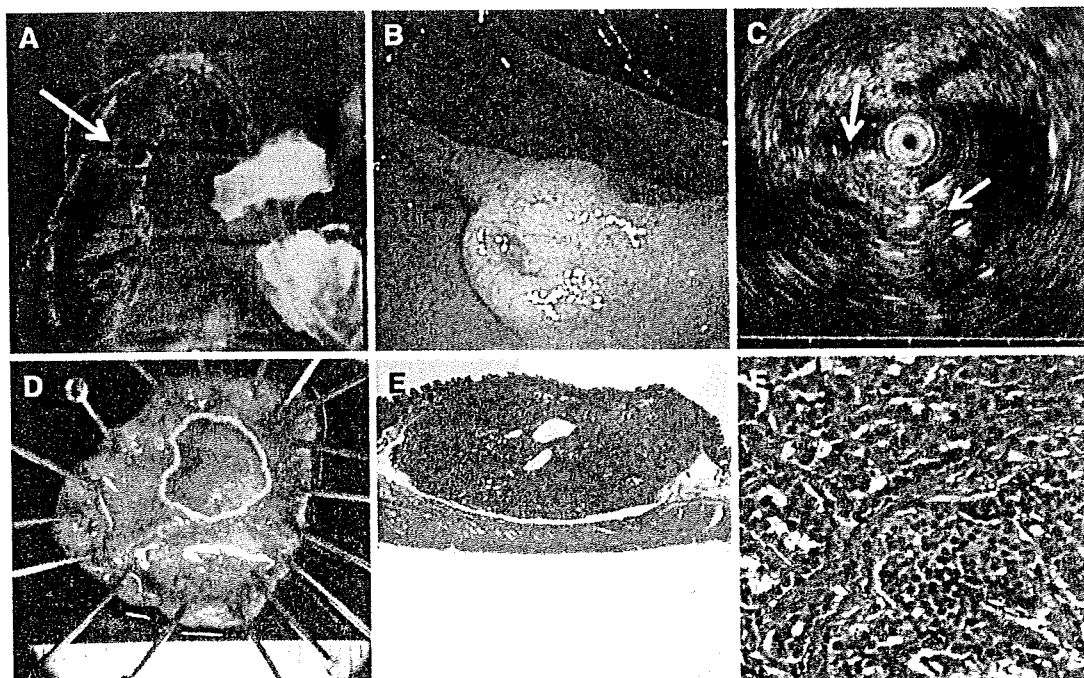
Images of the duodenal carcinoid tumor in our patient. A 76-year-old man was diagnosed with a duodenal submucosal tumor, which was <1 cm in size and located in the second portion of the duodenum (A, B). Endoscopic ultrasonography (EUS) demonstrated that the tumor had spread to the mucosa and the submucosa, and there was no metastasis to the periduodenal lymph nodes (C). Macroscopic
